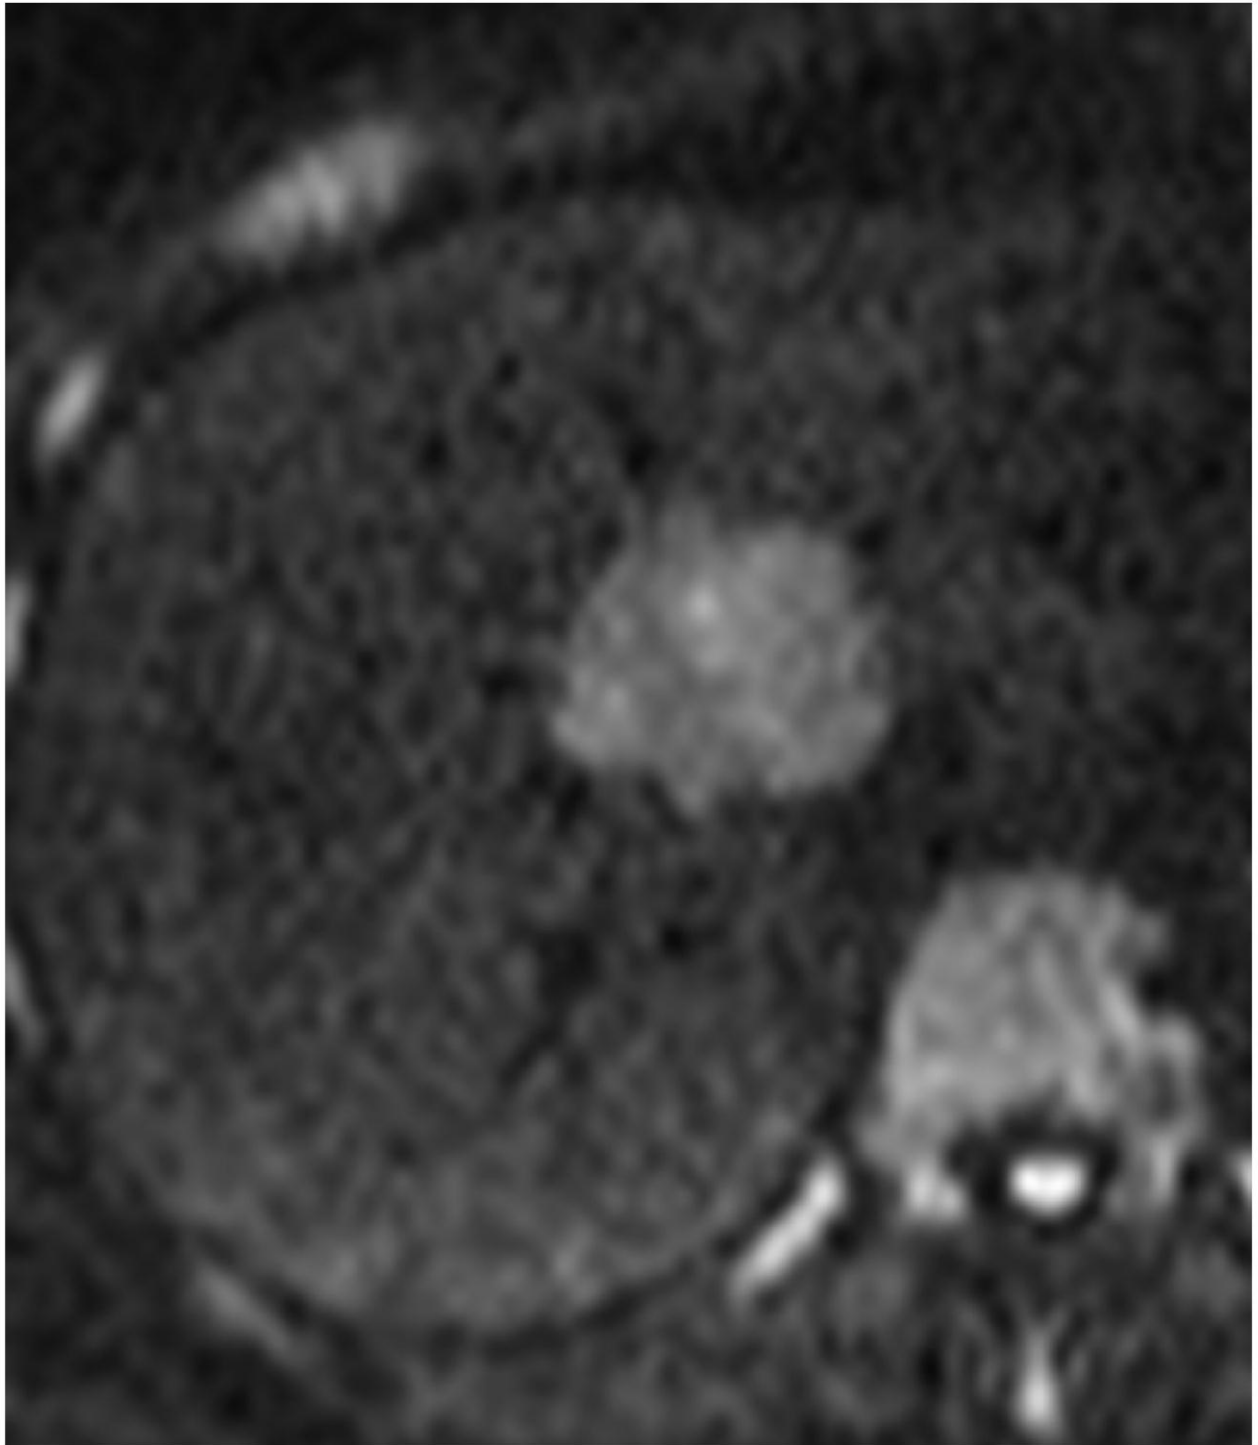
Diffusion-weighted MRI, b-value=800. FNH shows restricted duffusion.
